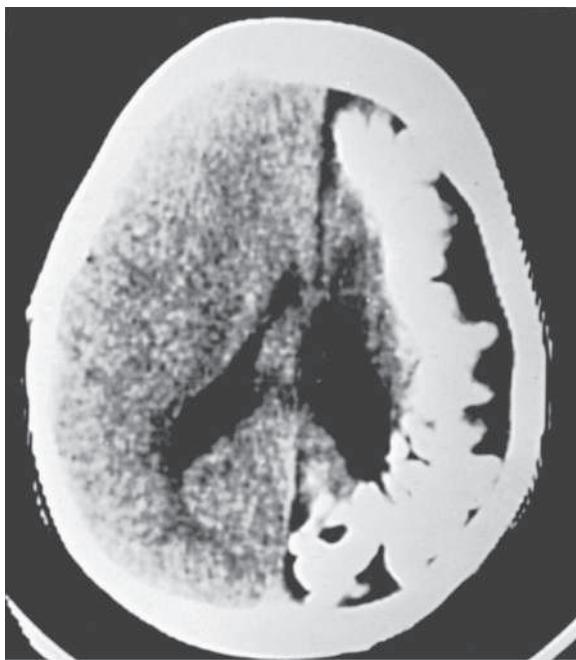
CT scan of a patient with Sturge-Weber syndrome showing unilateral calcification and underlying atrophy of a cerebral hemisphere.
